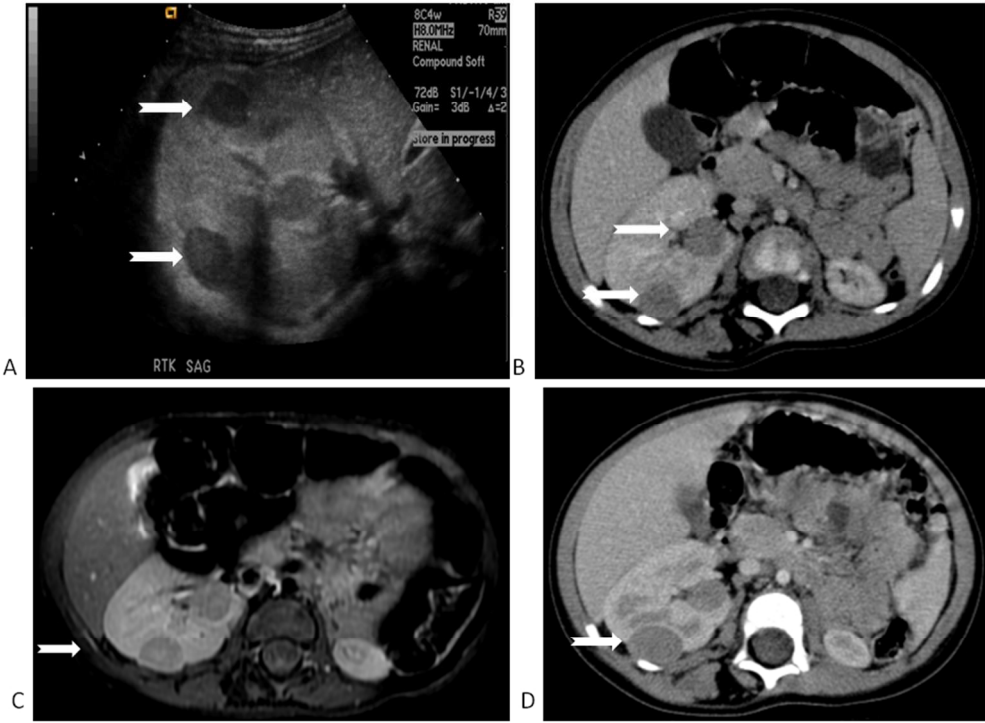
Ultrasound of Patient 1 obtained at age 9 months, showing multiple hypoechoic, avascular right renal masses in the lower pole and interpolar region (a); contrast enhanced CT scans at age 9 months (b) and 12 months (c) show well-defined low attenuation lesions enlarging in size in the hypertrophied right kidney. The left kidney is atrophied. (c) MRI demonstrates well defined lesions with mild heterogeneous internal enhancement.
